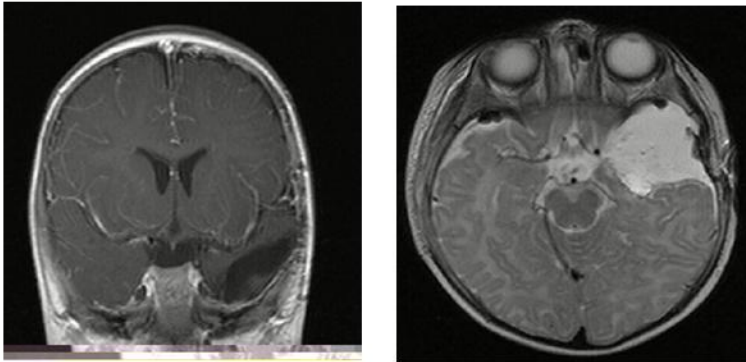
Postoperative enhanced T1-weighted (b) T2-weighted MRI scans demonstrating no residual tumour at the 5th year of age
